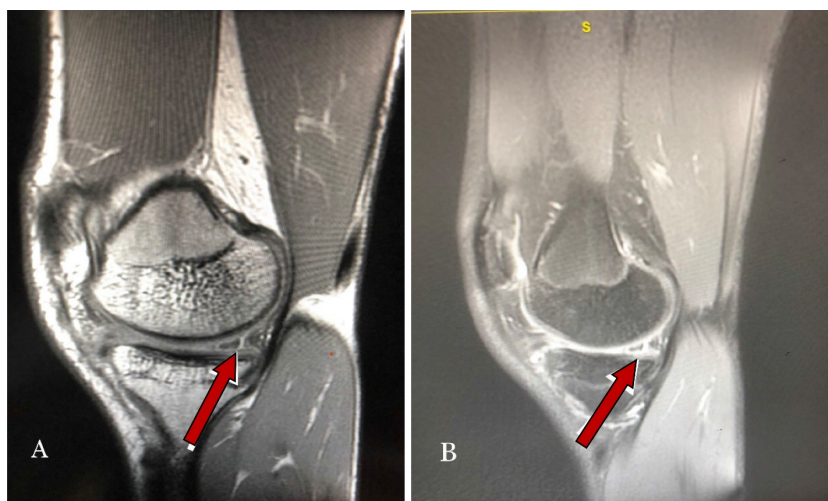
MRI reconstruction of the knee in T1 sequence (A) and T2 sequence (B) showing a radial tear of the posterior horn of the medial meniscus.
